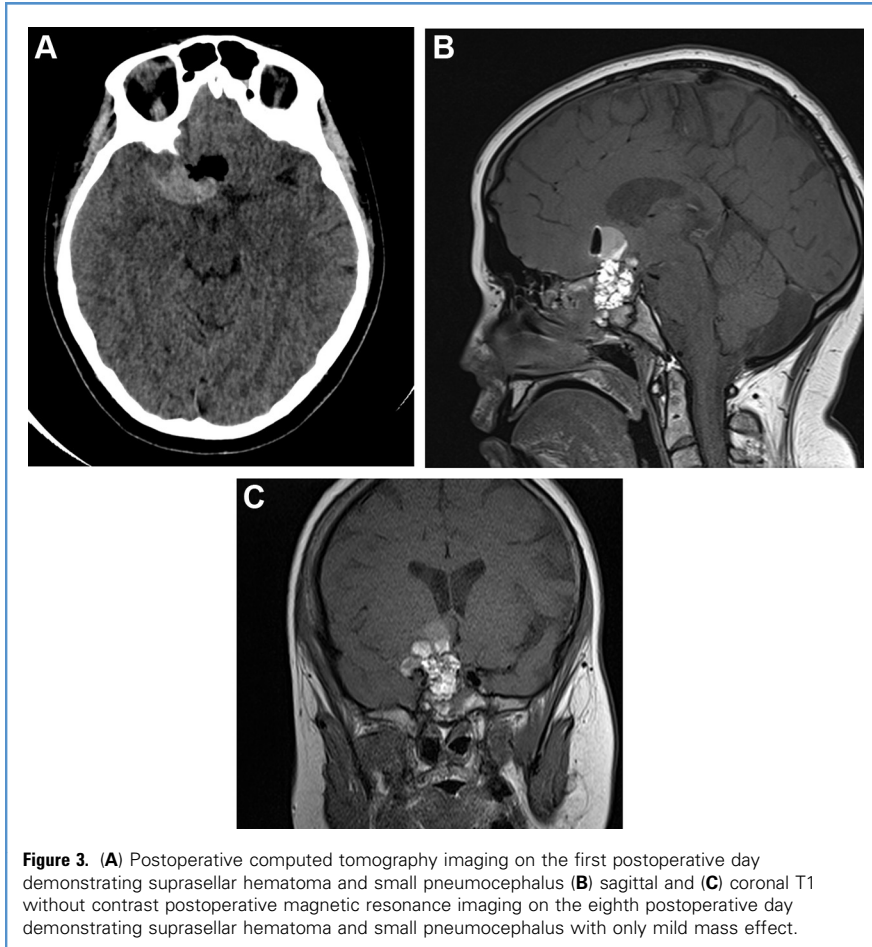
(A) Postoperative computed tomography imaging on the first postoperative day demonstrating suprasellar hematoma and small pneumocephalus (B) sagittal and (C) coronal T1 without contrast postoperative magnetic resonance imaging on the eighth postoperative day demonstrating suprasellar hematoma and small pneumocephalus with only mild mass effect.
